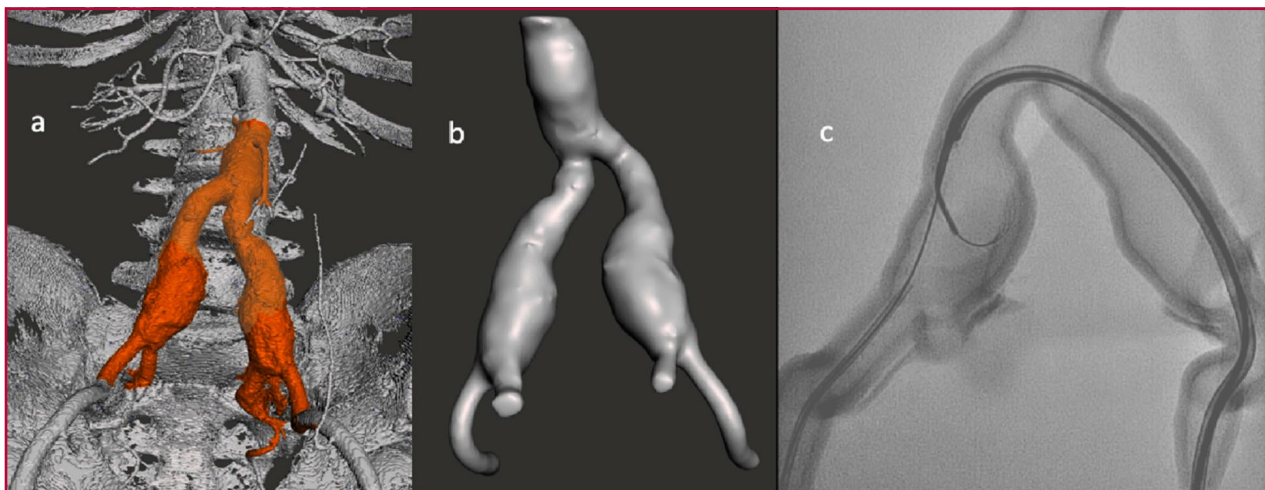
CT image (a) from which the 3D-impression is obtained. This impression is used for training in iliac branched stent-graft implantation (c)
